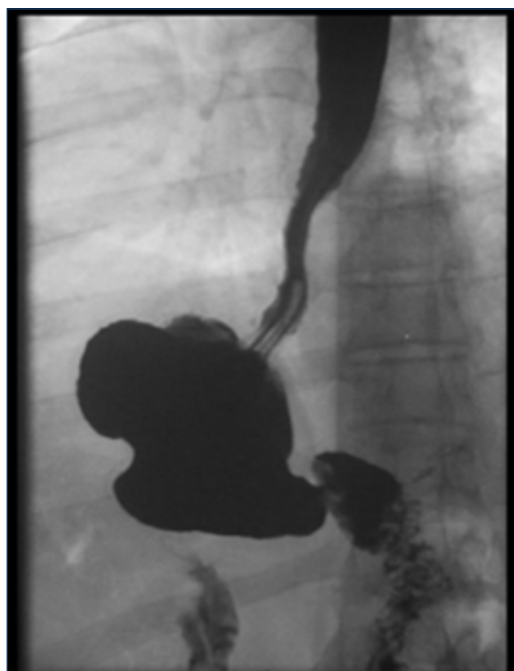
Barium test: gastric dilatation and abdominal CT: hiatal hernia type 1
